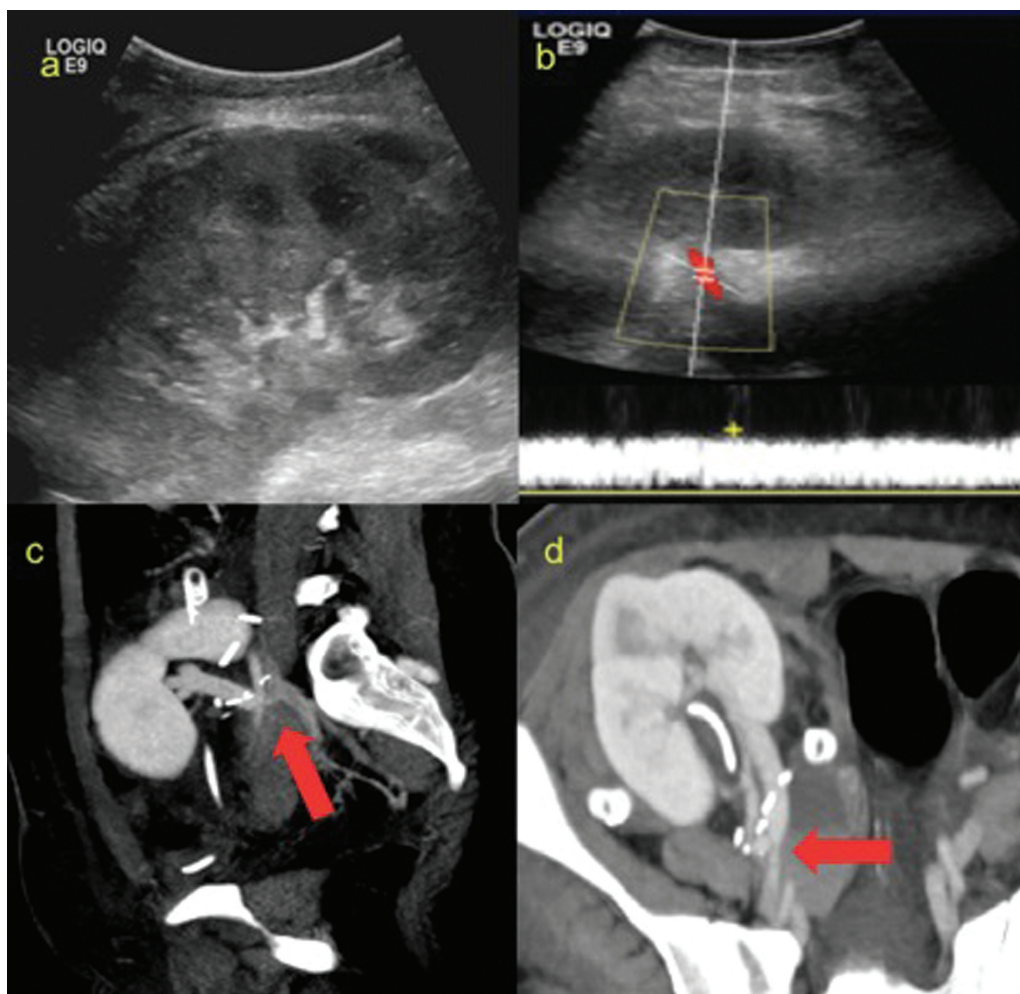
Ultrasound of the transplanted kidney image (a) showed an increase in the size of the transplanted kidney with increased cortical echogenicity. Spectral Doppler (b) showed flow within the main renal vein (MRV). However, the confluence of MRV with the external iliac vein (EIV) was not visualized. Contrast-enhanced CT images (c and d) in oblique sagittal section and MIP format shows tight focal stenosis of MRV (red arrows) at its anastomosis with EIV. CT, computed tomography.
